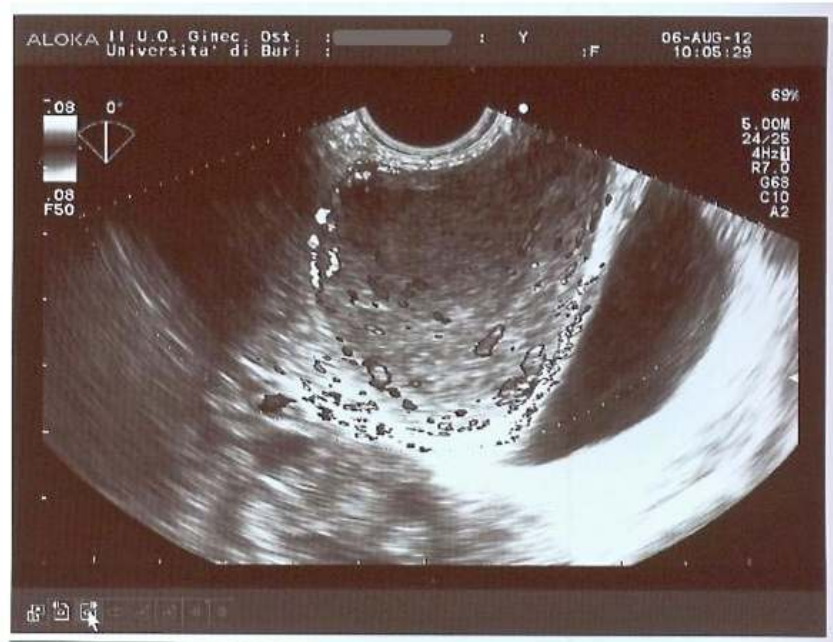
A: Transrectal 2D Ultrasonographic scan showing uterus (red arrow), vagina (white arrow) and the hyperechogenic inhomogeneous mass (black arrow). B: Transrectal ultrasound doppler of the mass showing peripheral vascularization
